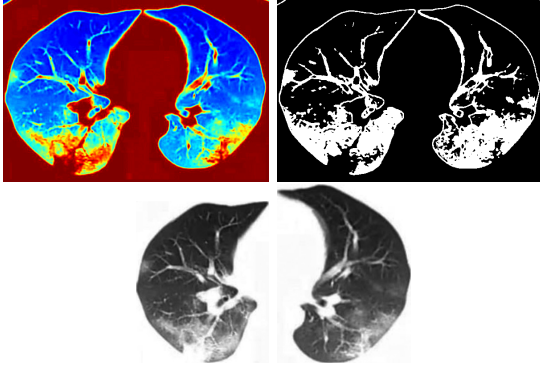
Pulmonary CT scan preprocessed using color mapping and thresholding and resulting lung sections
